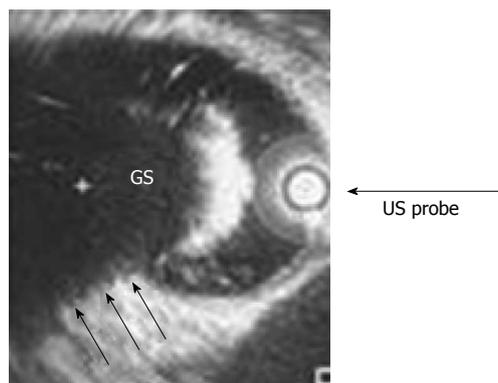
Intraductal ultrasound reveals a gallstone (labeled gallstone) in the common bile duct exhibiting acoustic shadowing (3 parallel arrows) in a middle-aged female patient presenting acutely with right upper quadrant pain, hyperbilirubinemia, and elevated aspartate and alanine aminotransferase levels. During pregnancy, endoscopic ultrasound provides a method to diagnose common bile duct stones without exposing the fetus to the risks of ionizing radiation from endoscopic retrograde cholangiography. US probe: Ultrasound probe; GS: Gallstone.
